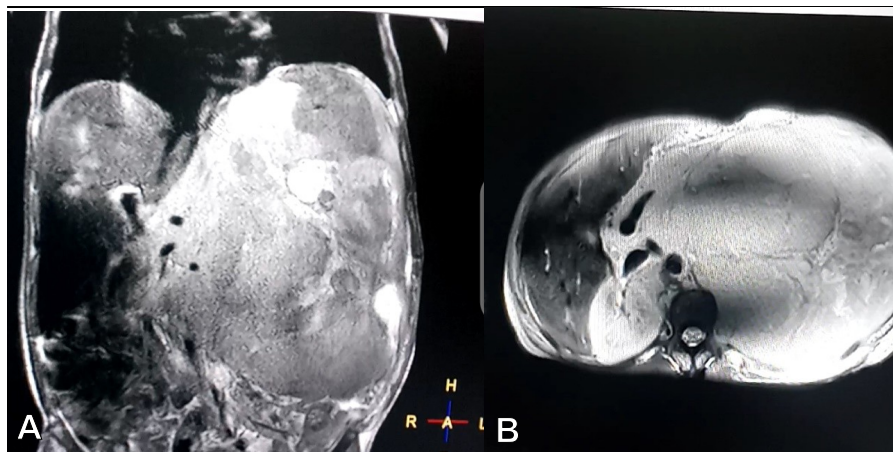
Abdominal magnetic resonance imaging (MRI) showing a large soft tissue retroperitoneal mass; A: Coronal view; B: Axial view.
